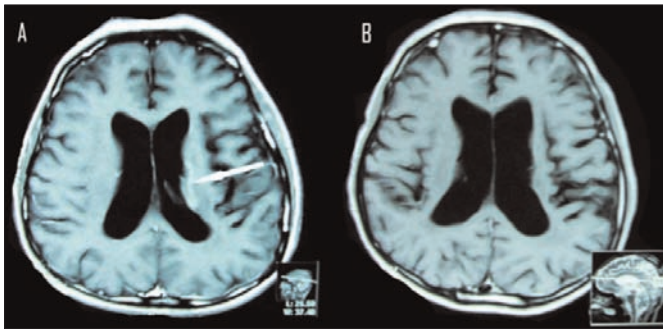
(A) MRI brain with contrast shows nodular area of the mass involving the thalamus measuring 2 cm transverse, 2 cm anteroposterior and 2.1 cm craniocaudal extent as indicated with white arrow (before Temozolomide). (B) No enhancement seen on contrast to suggest residual/recurrent disease.
